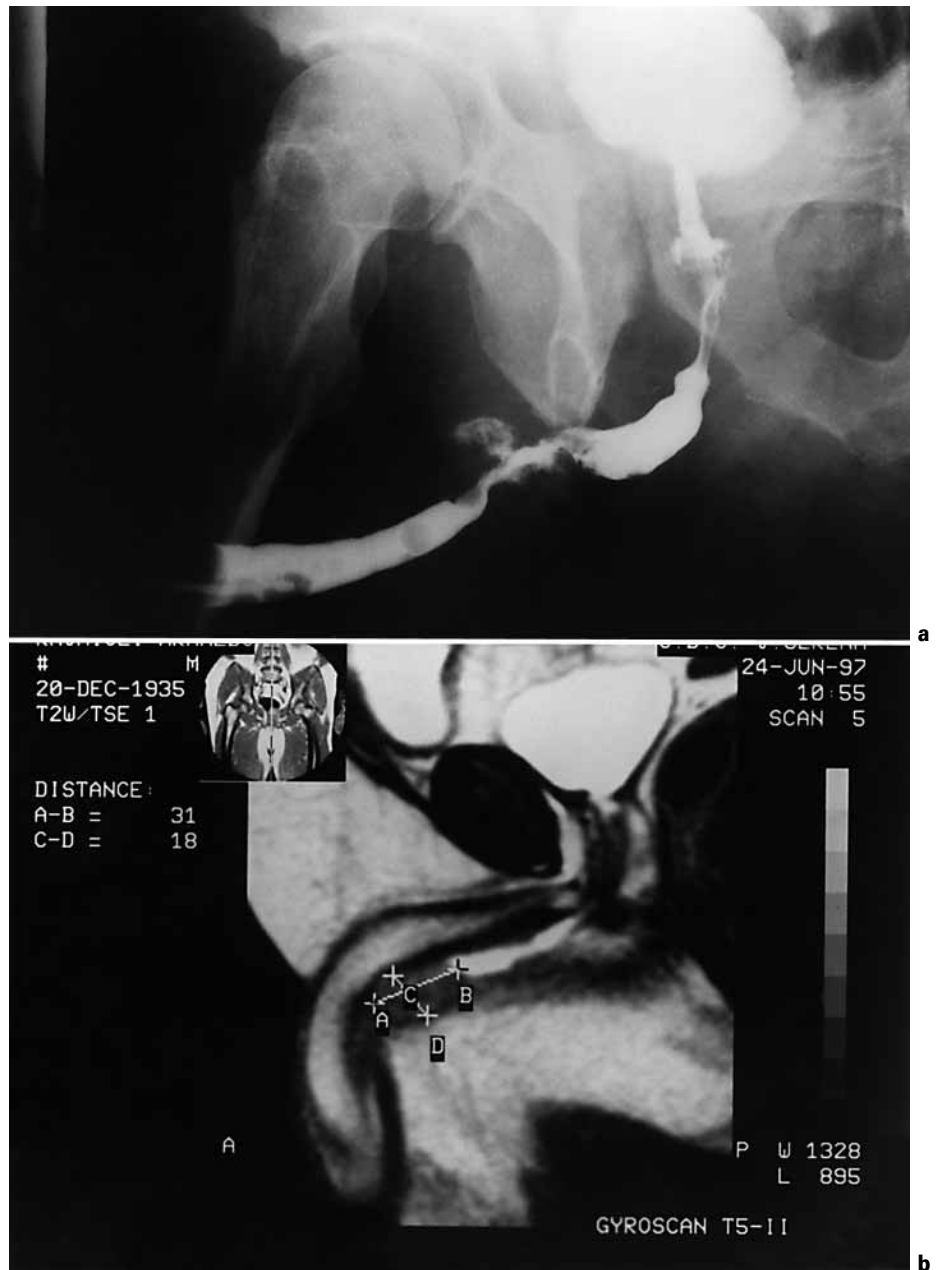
a Retrograde urethrogram. b Pelvic magnetic resonance imaging, sagittal view, demonstrating recurrence of an urethral bladder carcinoma in a patient with orthotopic ileal ladder.
